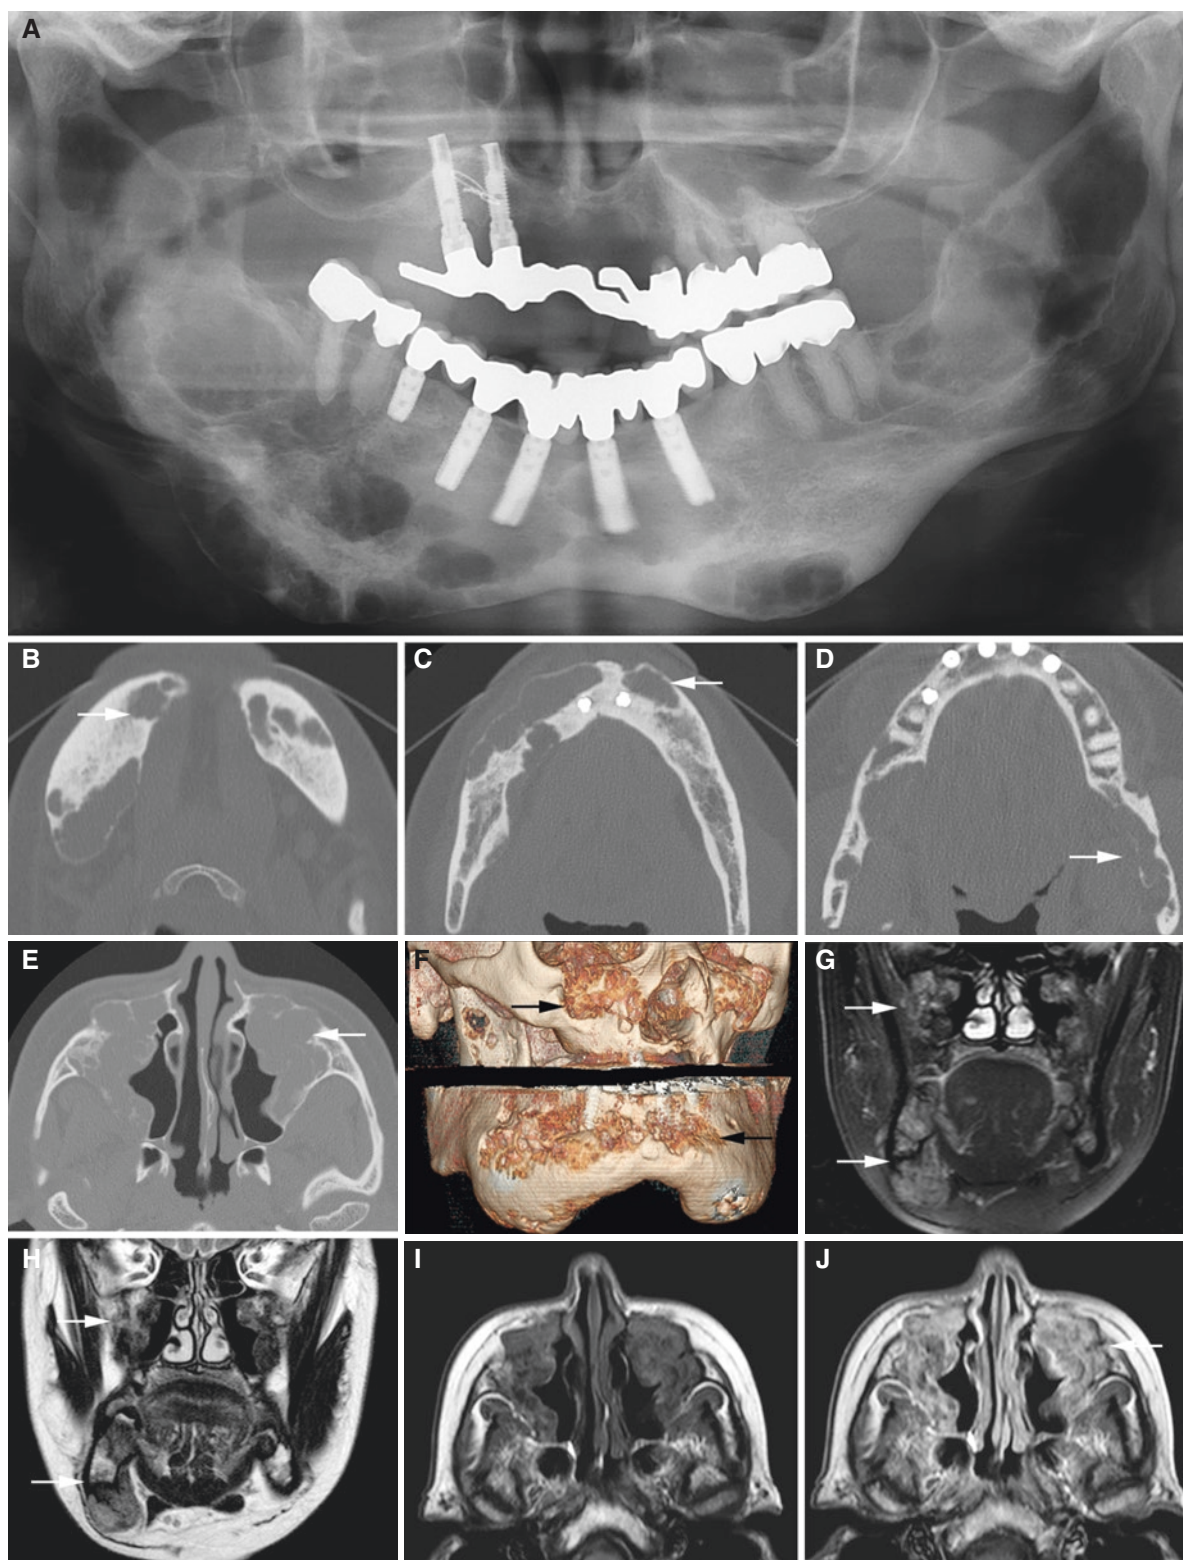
Cherubism; 49-year-old female. (A) Panoramic view shows multilocular and monolocular radiolucencies in the mandible. (B, C, D) Axial CT images confirm radiolucencies in the mandible (arrow). (E) Axial CT image shows radiolucencies also in the maxilla (arrow). (F) 3D CT images of the maxilla and mandible show deformities in both
